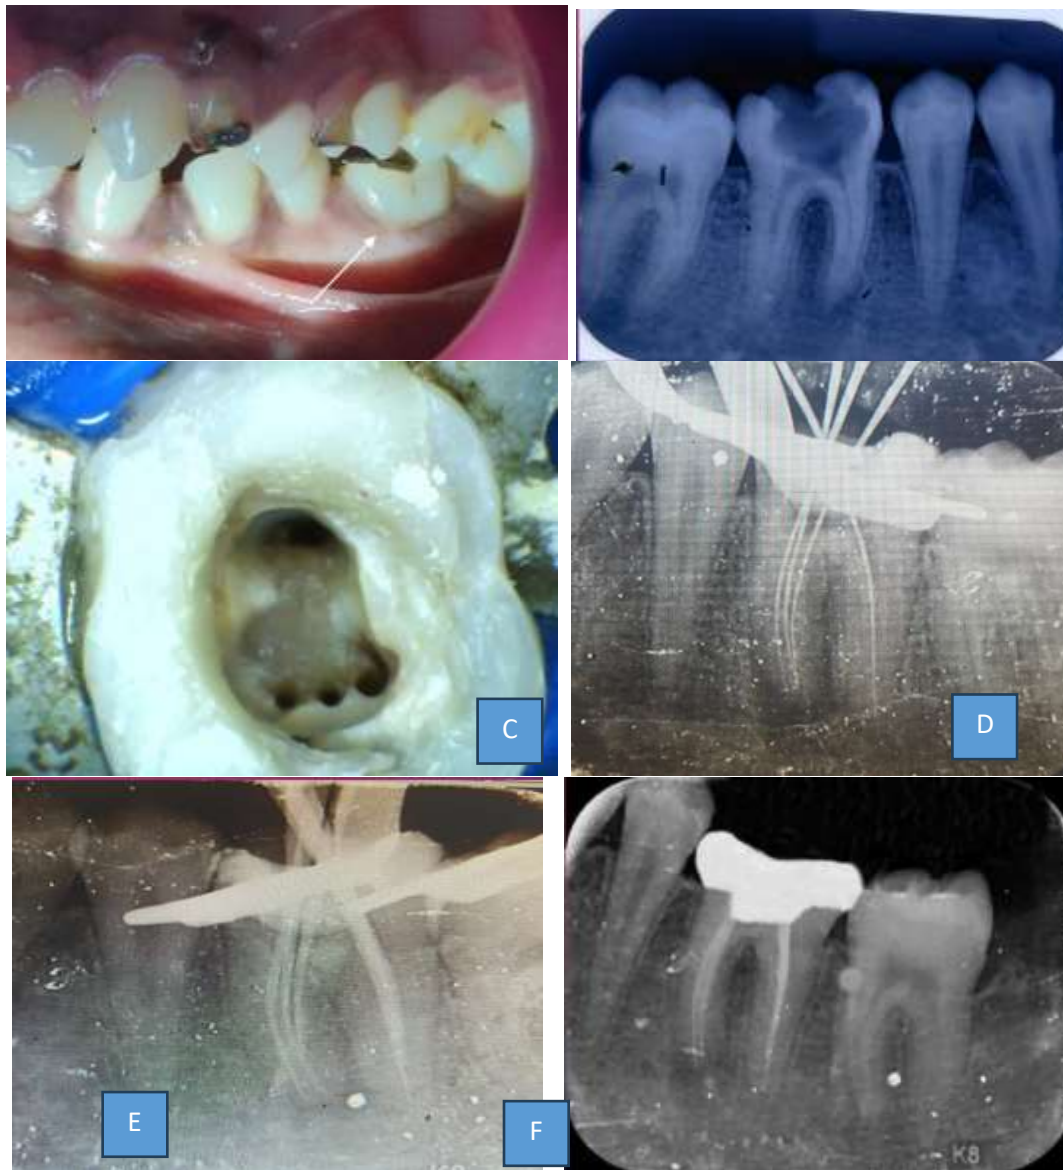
(A) Clinical Image (B) Preoperative Radiograph (C) Access Cavity (D) Working Length Radiograph (E) Master-cone Radiograph (F) Obturation Radiograph
